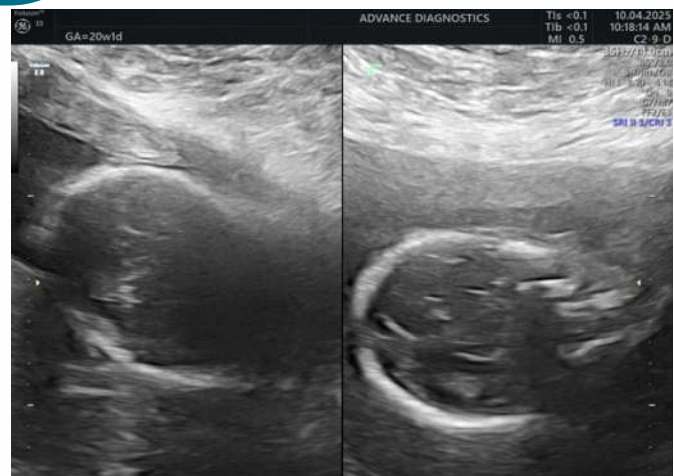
Showing thick layer of anterior abdominal fat causing scattering of the ultrasound waves with poor visualization of the fetal anatomy.
